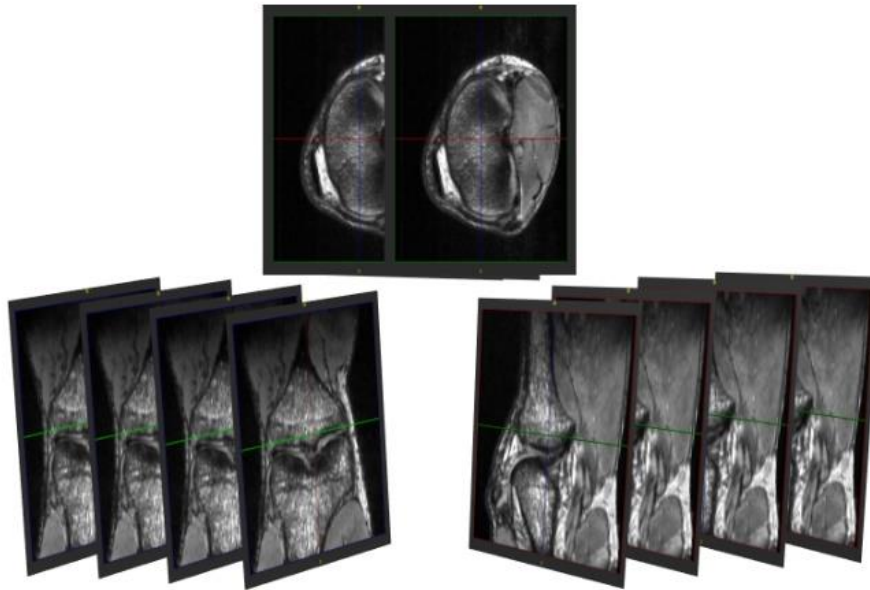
Bio-CAD MRI based technique for modelling the human knee
